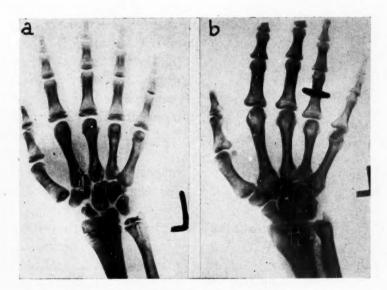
(Case 5.) a, roentgenogram of hand of cretin eighteen years old with concurrent thyroid deficiency in which previous treatment was inadequate. b, after three years of treatment resulting in complete epiphyseal closure. Note dense and widened phalangeal bones due to long-standing hypothyroidism. Height age at eighteen years was eight years; at twenty, ten years. Puberty began during the first year of treatment (see Fig. 4).
